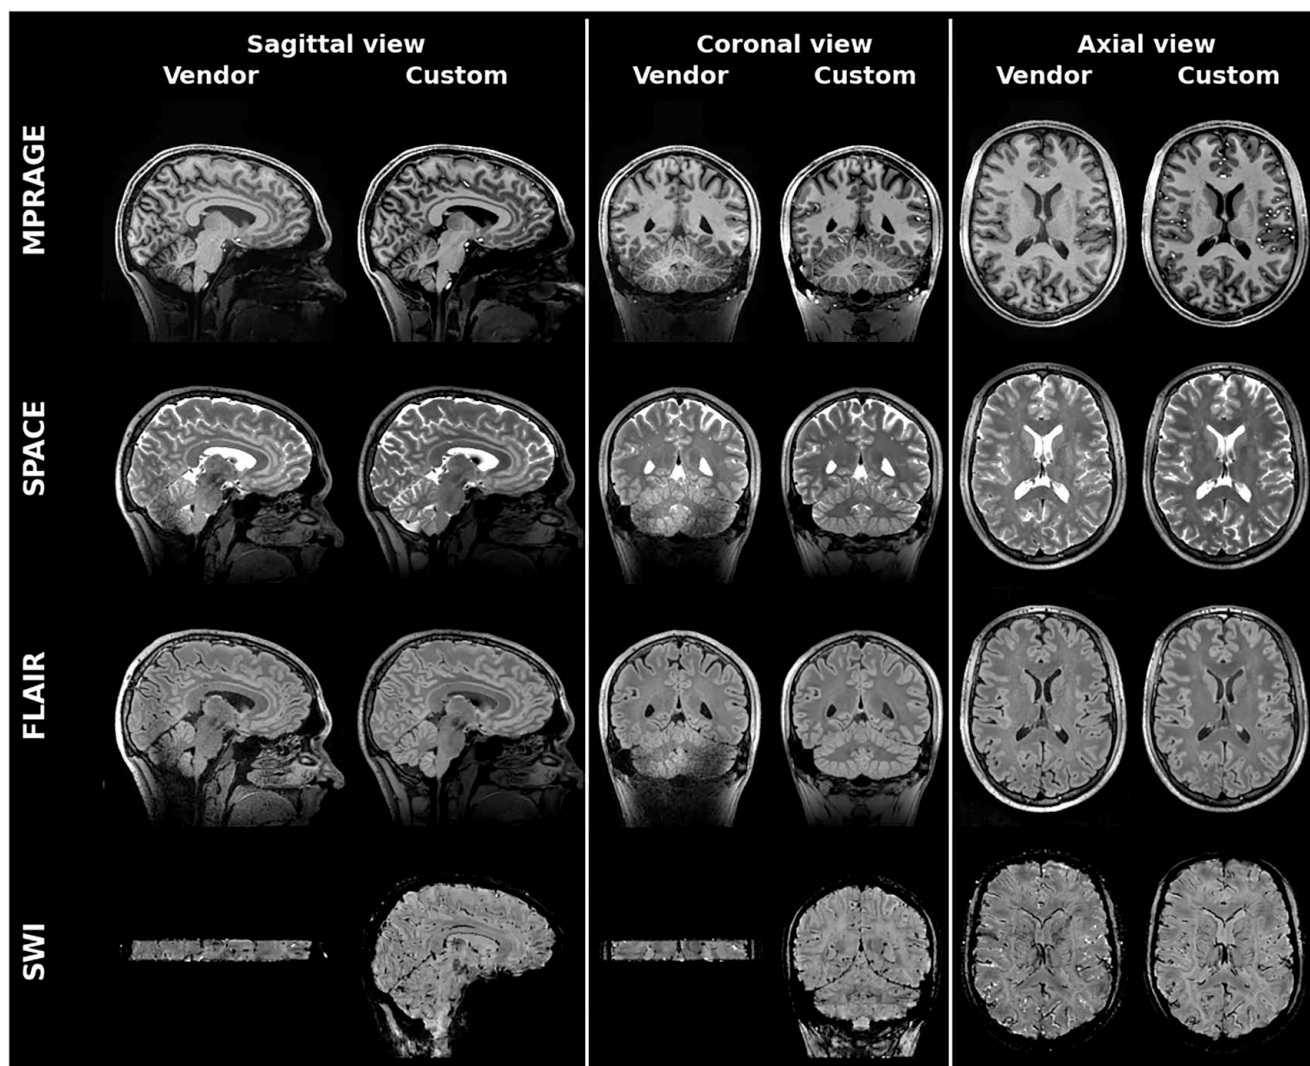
Anatomical images of one healthy volunteer. The columns compare sagittal, coronal, and axial views of acquisitions with vendor and custom sequences, respectively. The rows show contrasts obtained with different sequences: T_1 -weighting with MPRAGE, T_2 -weighting with SPACE, fluid-suppressed T_2 -weighting with FLAIR, and SWI with 3D-GRE (vendor) and 3D-EPI (custom). The vendor SWI can only cover a small FOV in the same acquisition time as compared with the custom SWI (cf. Methods section).
